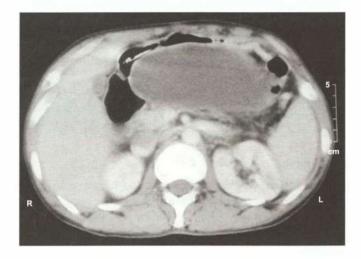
CT scan: Classical pseudocyst pushing the stomach anteriorly—cystogastrostomy is ideal treatment
